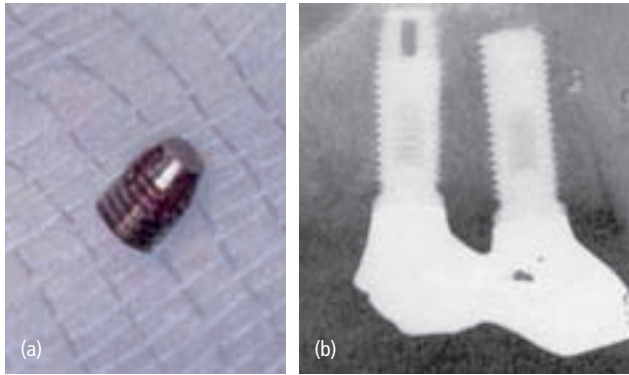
Symptomatic periapical lesion around an implant. (a) The apex of the implant was removed. (b) Healed apex of no. 4. (Courtesy of Dr Tarnow.)
